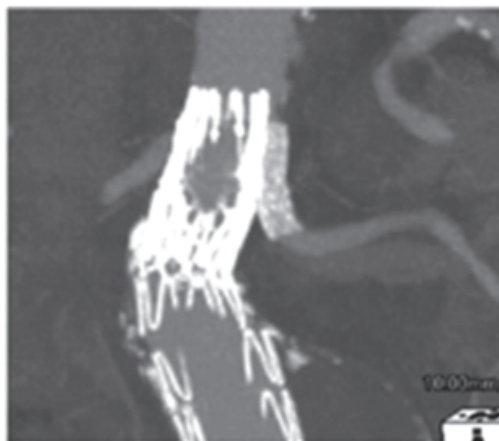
CT showing a snorkel graft.
